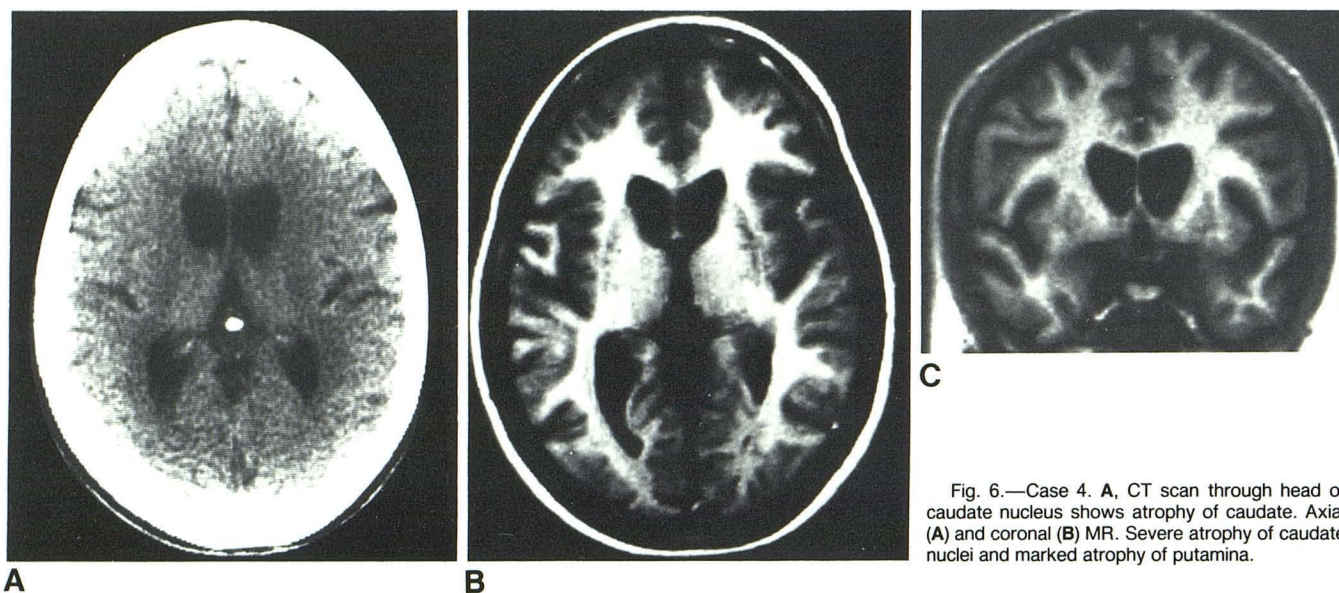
Case 4. A, CT scan through head of caudate nucleus shows atrophy of caudate. Axial (A) and coronal (B) MR. Severe atrophy of caudate nuclei and marked atrophy of putamina.
